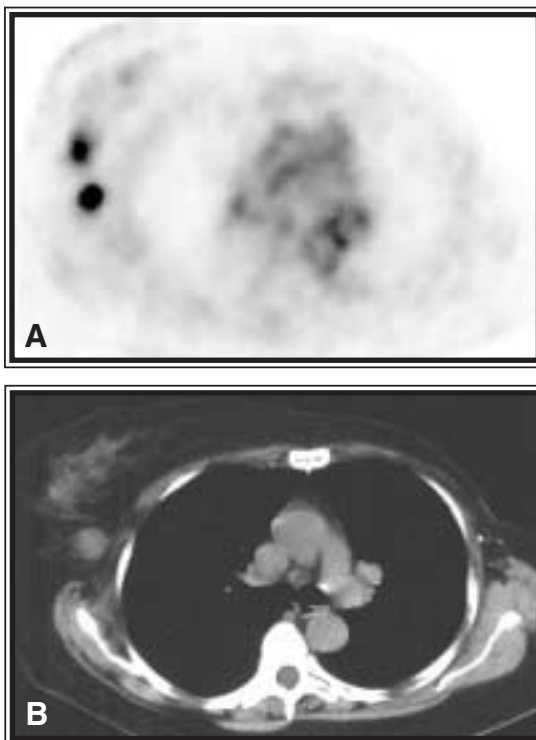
A: PET shows focal areas of intense FDG uptake in right breast and right axillary lymph node, suggestive of primary breast cancer with axillary lymph node metastasis. B: CT image of chest shows irregular density in right breast and enlarged right axillary lymph node.
